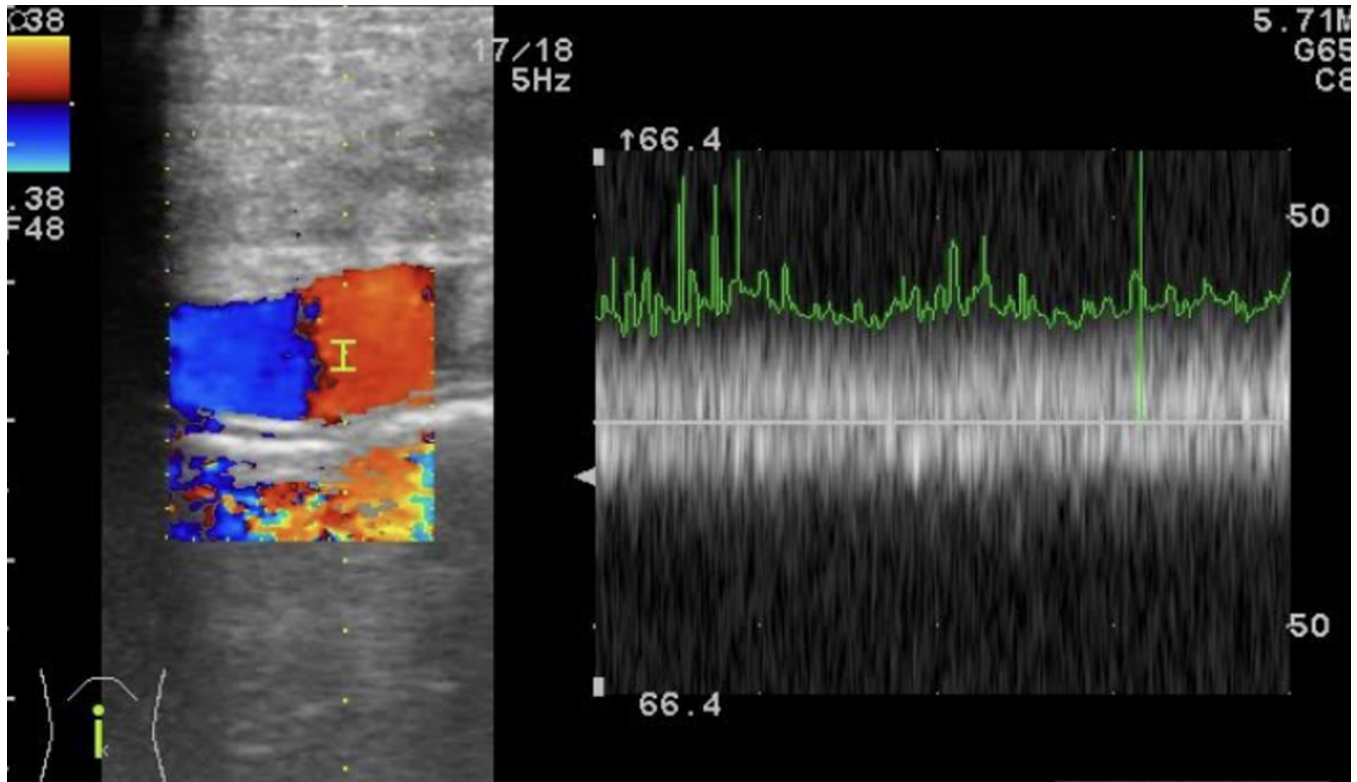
Transverse sections of US at the umbilical region shows dilated left paraumbilical vein. On color and spectral Doppler, it showed venous flow and waveform with a PSV of 33 cm/sec.
